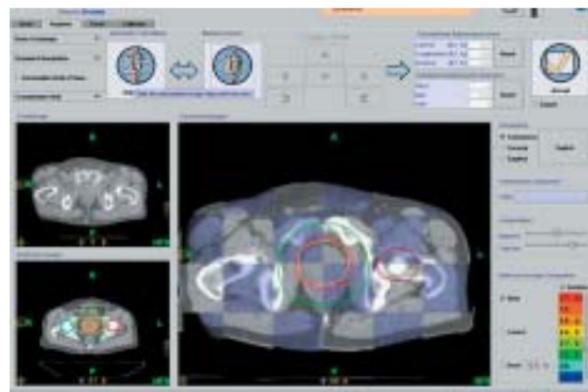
Adjustments in patient positioning are easily made, matching registered planning and daily CT images
